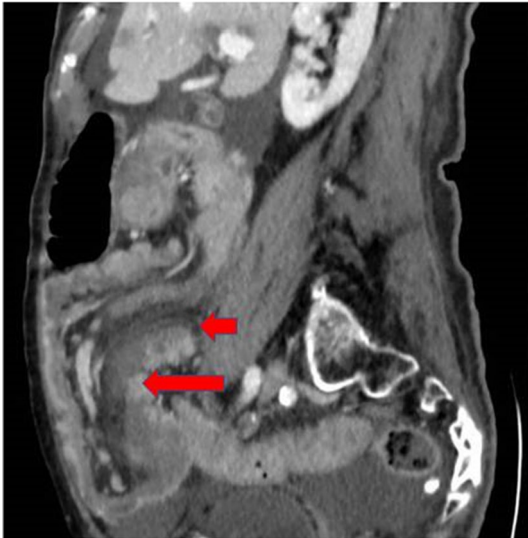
CT scan showing the presence of ileocecal intussusception in the sagittal plane (red arrows)
